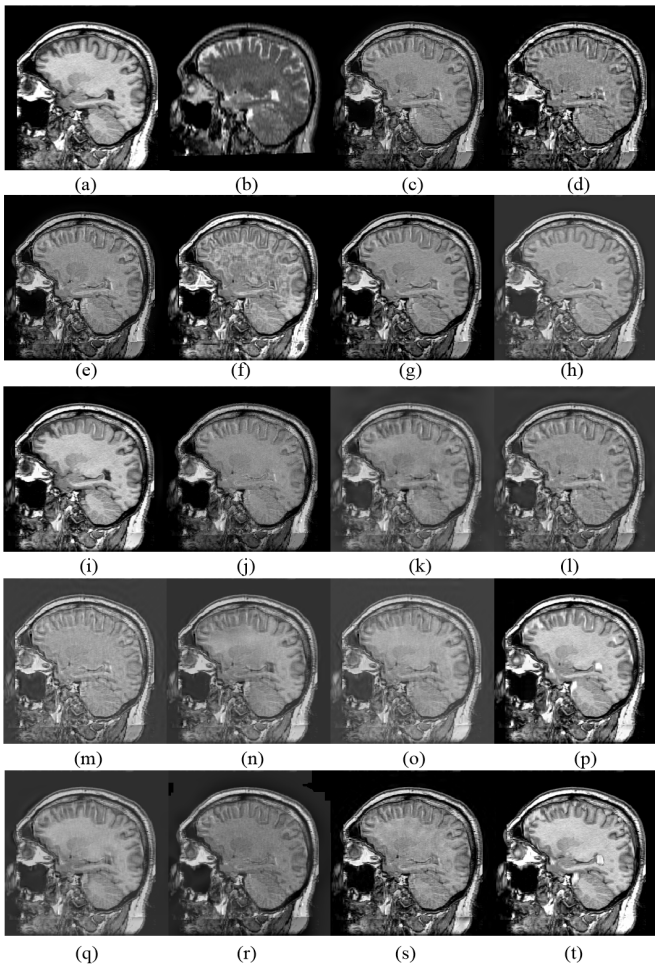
Experiments for S4. (a) CT. (b) MRI. (c) GP [52]. (d) DWT [52], [53]. (e) fsdP [52]. (f) GFS [54]. (g) CSR [55]. (h) ASR [56]. (i) GFF [57]. (j) MSVD [58]. (k) DTDWT [59]. (l) SWT [60], [61]. (m) CVT [62]. (n) DTCWT-SR [63]. (o) CVT-SR [63]. (p) LRSDL [64]. (q) PCLLE [65]. (r) MSGIF [66]. (s) DCHWT [67]. (t) Proposed.
